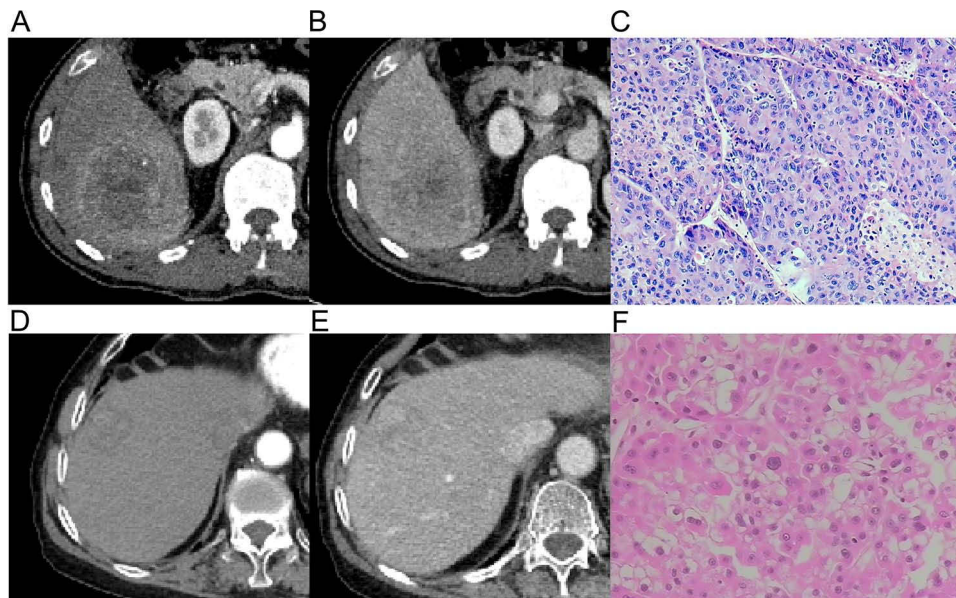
Representative CT and pathological images of PHCC and NPHCC. (A–C) PHCC: MTM-HCC subtype, male, 58 years old. The tumor shows a blurred boundary with an incomplete capsule and extensive intratumoral necrosis. Heterogeneous AP enhancement with intralesional vessels is visible (RFS = 19.2 months). (D–F) NPHCC: Clear cell subtype, female, 70 years old. The tumor has a well-defined boundary, shows AP enhancement, and maintains enhancement in the PVP. No postoperative recurrence occurred. Abbreviations: CT, computed tomography; PHCC, proliferative hepatocellular carcinoma; NPHCC, non-proliferative hepatocellular carcinoma; MTM-HCC, macrotrabecular-massive hepatocellular carcinoma; AP, arterial phase; RFS, recurrence-free survival; PVP, portal venous phase.
